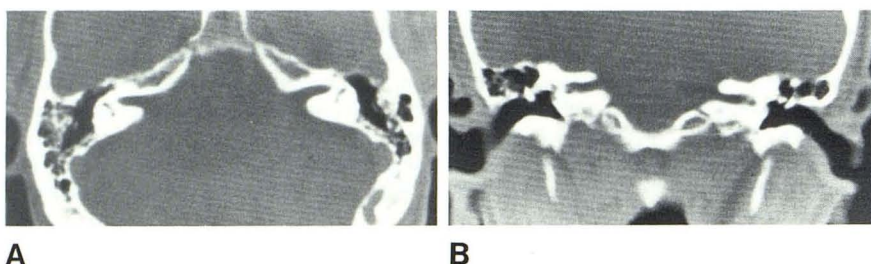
Normal internal auditory canals in patient with left-sided tinnitus but no hearing loss. A, Axial CT shows mildly patulous canals and slight asymmetric anteversion on left. B, Coronal CT shows no significant medial narrowing because canals are relatively straight.
